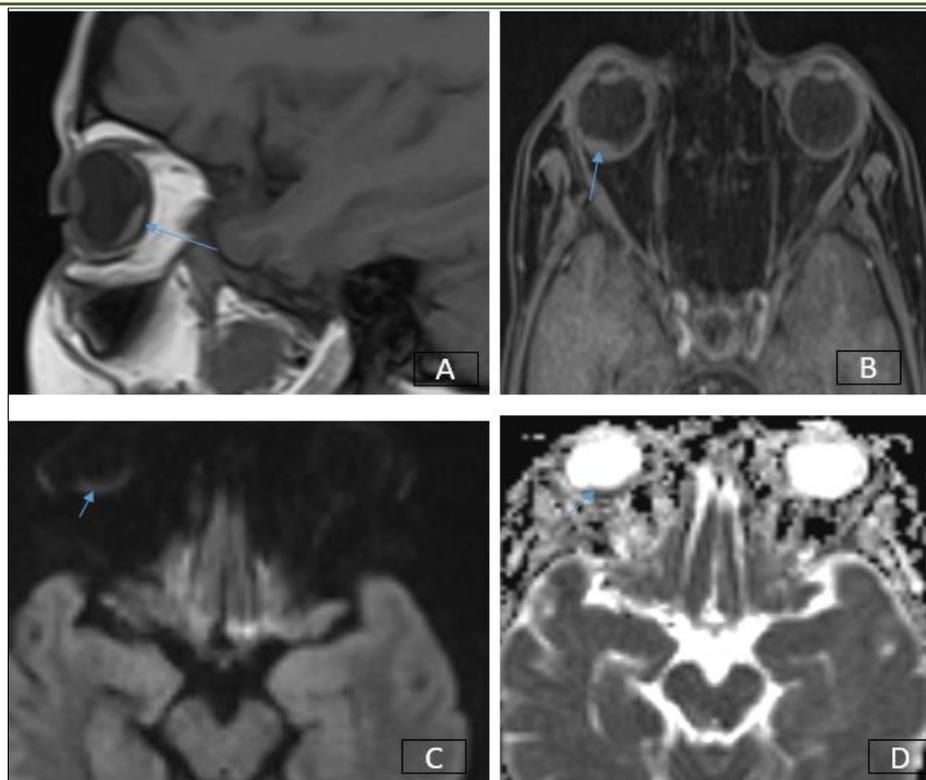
Oculo-orbital MRI with T1-weighted sequence (A) and T1-weighted sequence with gadolinium contrast (B), diffusion-weighted imaging (C) with apparent diffusion coefficient (ADC) mapping (D), revealed nodular choroidal thickening in the upper external quadrant of the right eye (arrow). The lesion demonstrated iso-intensity on T1-weighted imaging and diffusion restriction. It exhibited homogeneous enhancement with gadolinium contrast and measured 13x3mm
